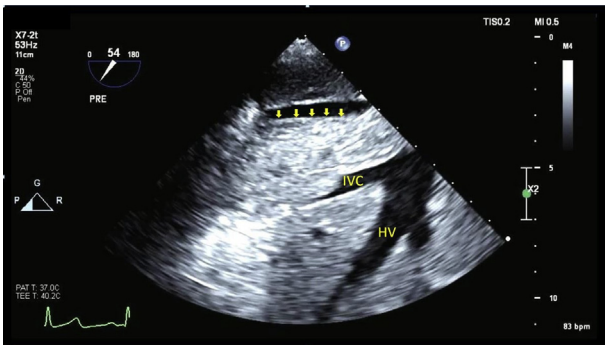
Transesophageal echocardiographic view of the IVC and hepatic vein (HV) shows tumor/thrombus (arrows) involvement of the IVC.
